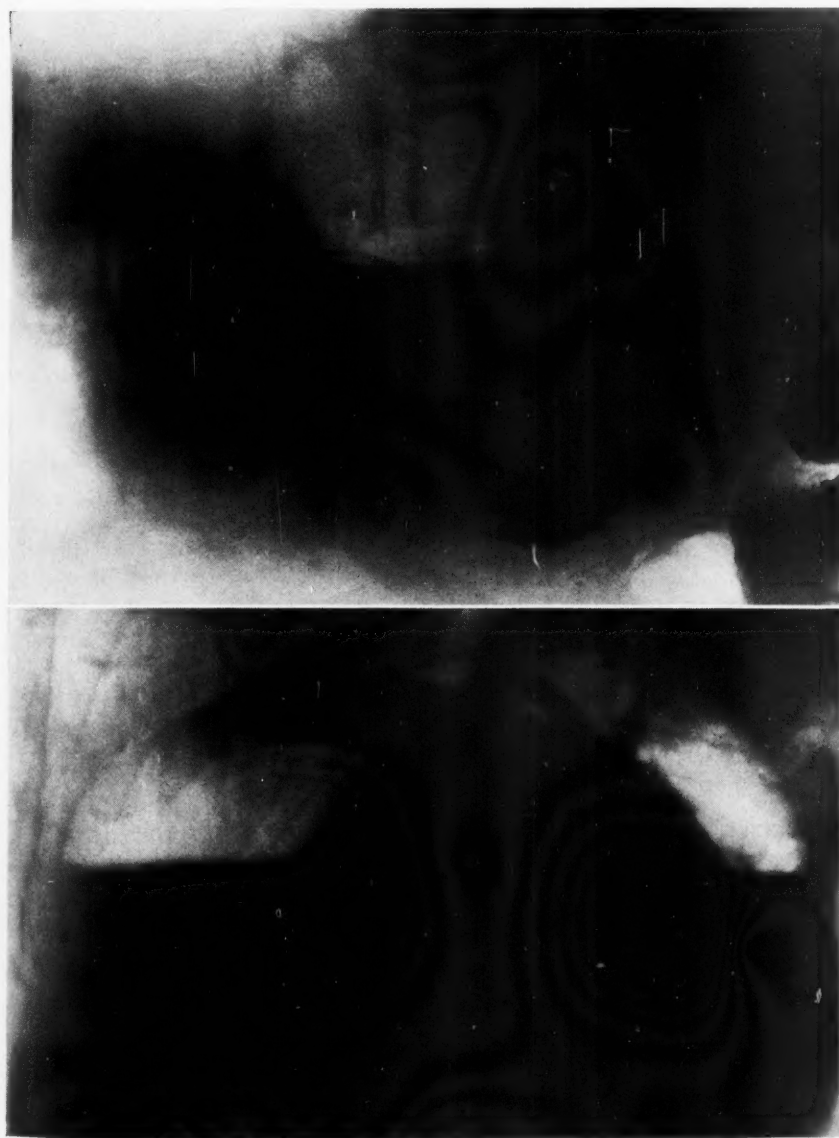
(*above*). Case 1. Subphrenic abscess. A postero-anterior roentgenogram, taken in the erect position, shows an elevation of the left diaphragm with much gas beneath it. The outer portion of the gas bubble is devoid of structure, a situation as seen in pneumothorax and pneumoperitoneum. The left diaphragm is thickened, there being an area of increased density just above it which is due, in part, to lung compression and in part to pleural fluid, as the infection travels upward through the diaphragm to involve the pleural cavity. Fluoroscopic examination shows no motion of the left diaphragm on respiration.
